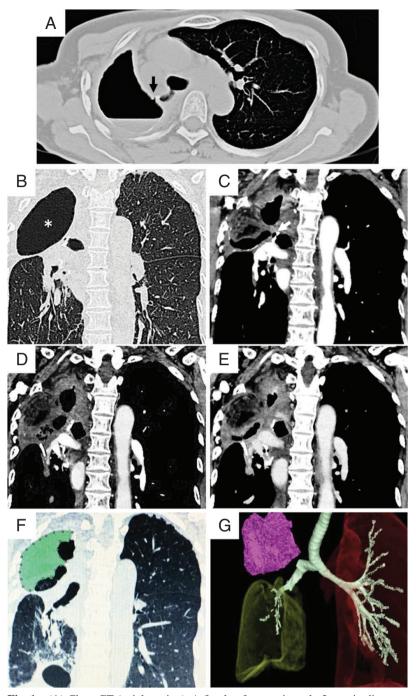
(A) Chest CT (axial section). A fistula of approximately 2 mm in diameter was observed between the right upper bronchial stump and the pleural cavity (black-arrow). (B) Chest CT (coronal section). A dead space (asterisk) was confirmed. (C) Chest CT after muscle flap transposition showed a reduction of the cavity, but the communication between the right bronchial stump and the dead space remained (white arrow). (D) Chest CT after the first VAC treatment indicated the reduction of the empyema cavity with extension of the transposed muscle flap. (E) The tendency of cavity reduction was more pronounced after the second VAC treatment. (F and G) The areas of the muscle flap were manually measured from each captured CT images and the volumes were obtained by integrating the areas of the muscle flaps. CT: computed tomography; VAC: vacuum-assisted closure
